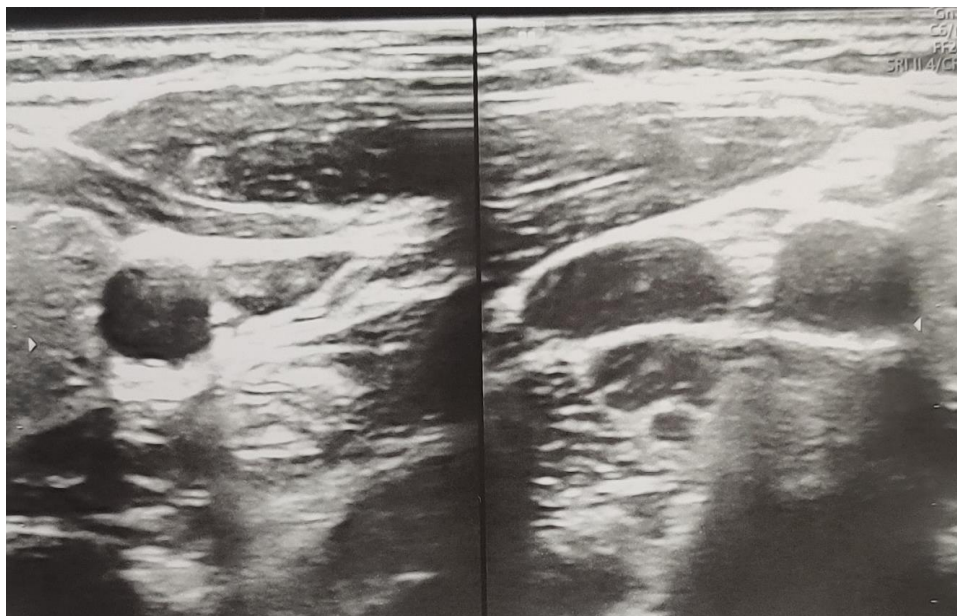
Ultrasonography showing well-defined, hypo-echoic, oval mass with internal echoes in the left submandibular region.
